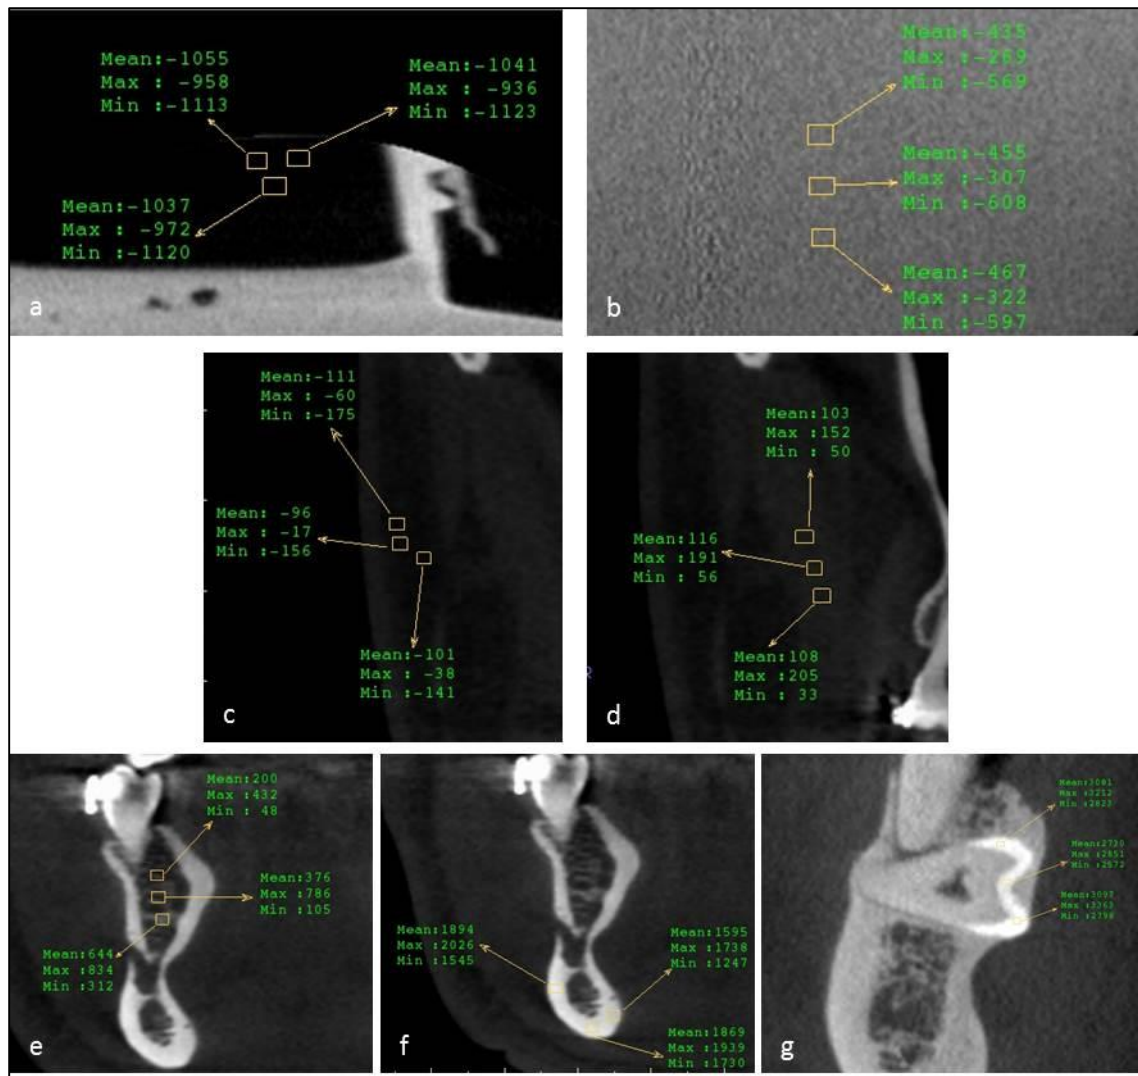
(a-g) – Representative CBCT images of each type of tissue and grayscale values for each tissue. A: air, b: water, c: fatty tissue, d: muscle tissue, e: trabecular bone, f: cortical bone, g: enamel.
